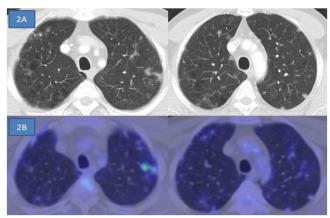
Thorax computed tomography. Multiple bilateral pulmonary nodules (the largest 20 mm) with variable border features detected predominantly in the upper lobe, some with opaque glass densities (A). Pet-CT: A large number of nodules observed in both lung parenchyma, with mildly elevated FDG uptake (early SUV max: 2.18, late SUV max: 3.14) (B)
